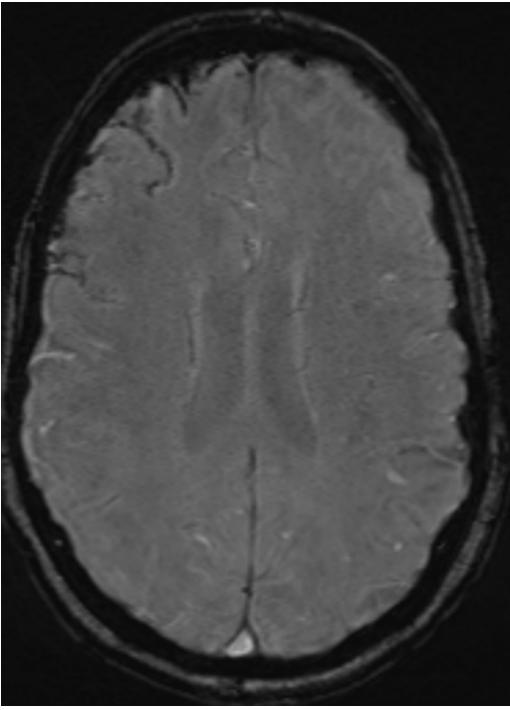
FLAIR sequence showing Right frontal convexity acute sub arachnoid hemorrhage
